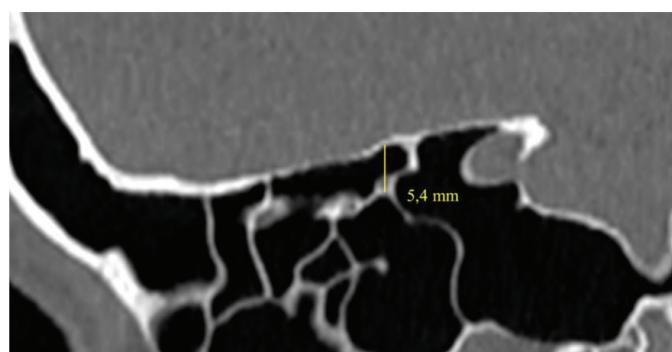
Distance between the posterior ethmoidal artery and skull floor on CT scan of patient Ho Thi T. Source: Dang Vuong Kiet, 2023.
